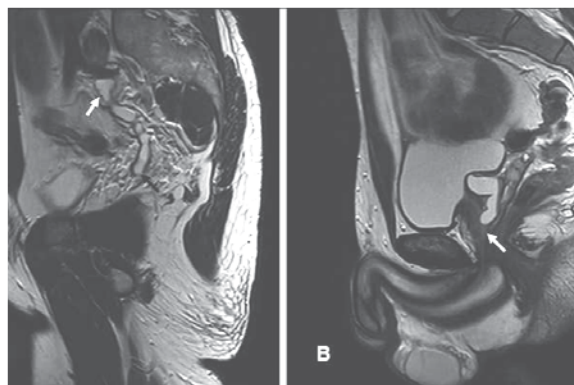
Magnetic resonance imaging (MRI) showing the small dysplastic kidney (white arrow) in the left retroperitoneum and the distended and convoluted ectopic ureter (black arrow).
